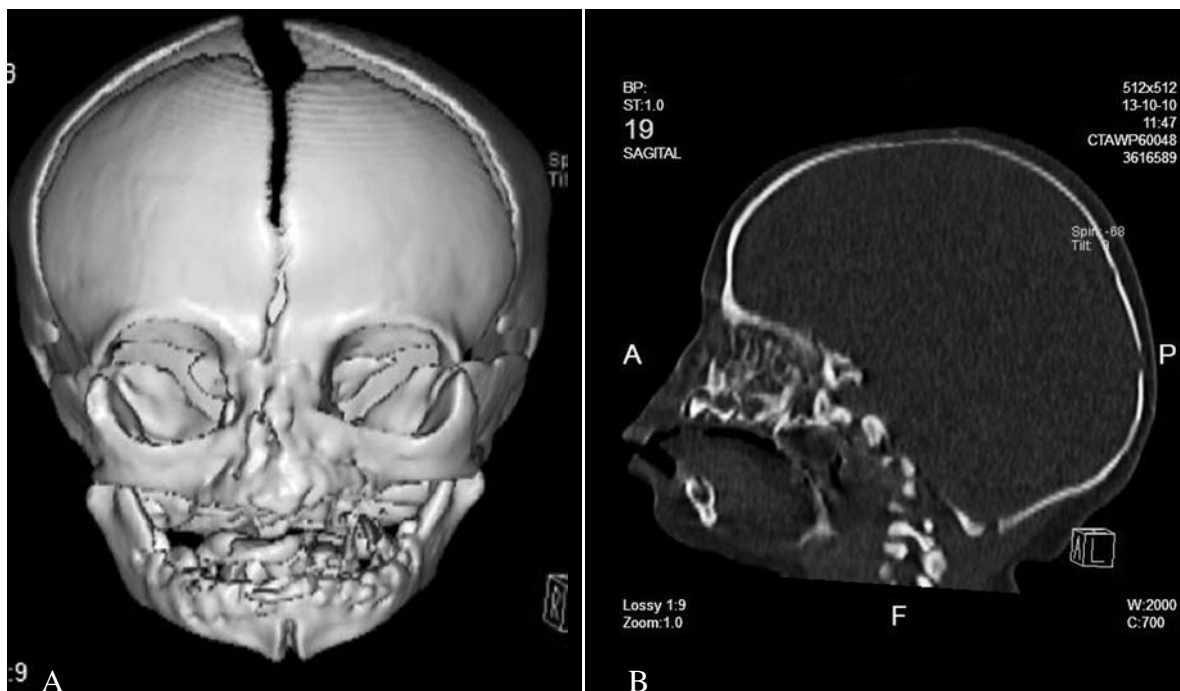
Three-dimensional computed tomography scan showing nasal bone hypoplasia. 2b. A sagittal section of computed tomography showing the absence of the nasal bony structures.
